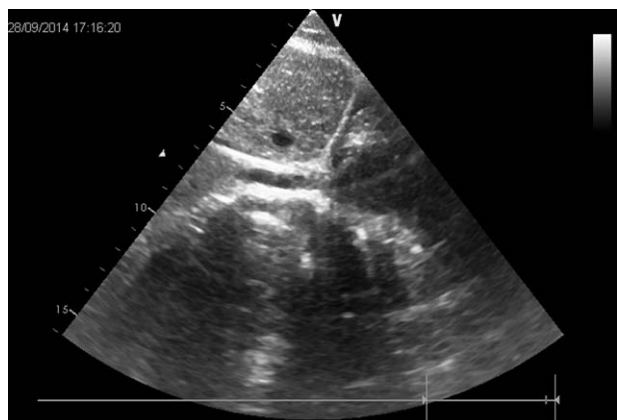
A multifunctional catheter was advanced into the right atrium via the inferior vena cava under the guidance of echocardiography.
